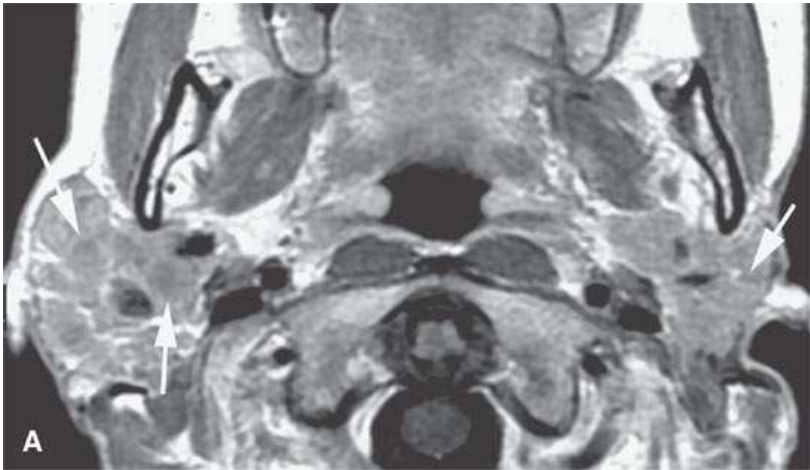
Magnetic resonance imaging studies of a patient with long-standing Sjögren disease with a secondary lymphoma. A–C: Confluent masses showed progressive enlargement on serial studies (*arrows*). Confluent masses are not necessarily due to lymphoma in this setting; however, their progressive enlargement (*arrowheads*) prompted biopsy to reveal lymphoma. A: Contrast-enhanced T1-weighted image. B, C: T2-weighted images.
